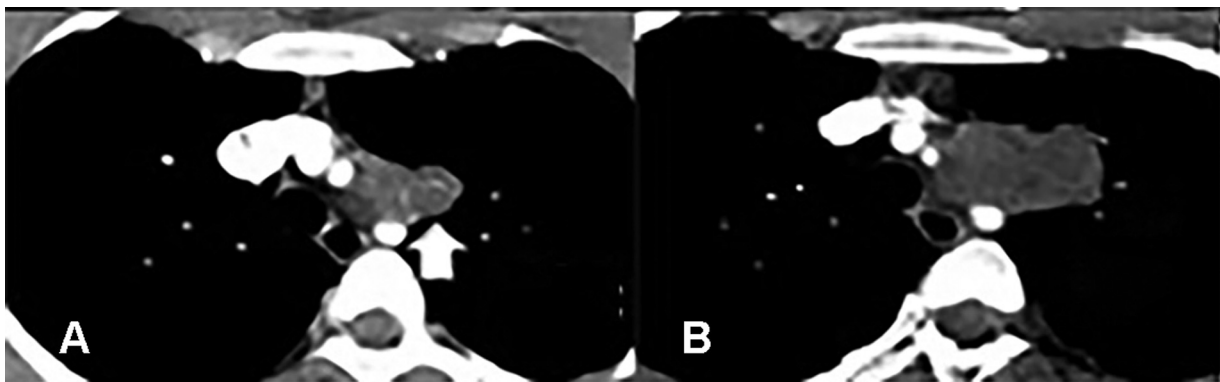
Prechemotherapy axial contrast-enhanced computed tomography (CECT) image of thorax (A) showing a conglomerate enhancing prevascular mediastinal nodal mass (arrow in A) with prominent vessels supplying it. Postchemotherapy axial CECT images of thorax (B), showing significant increase in size with reduction in the enhancement, more cystic/necrotic areas and decrease in the vascularity as compared with the prechemotherapy scan.
